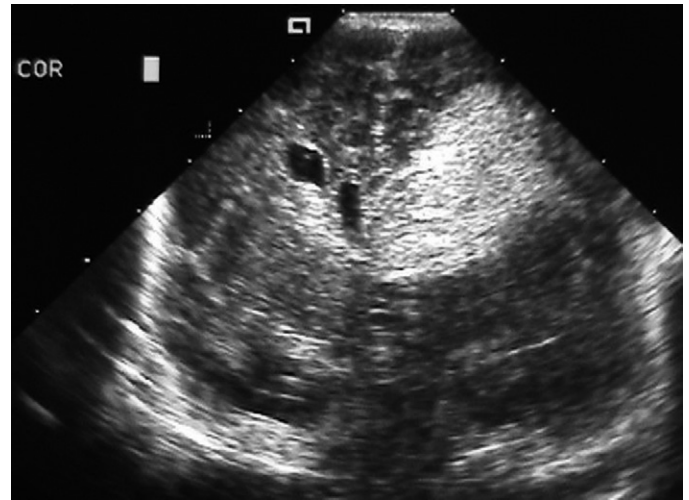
■ Coronal ultrasound scan—note the increased echodense area in the left frontal white matter conforming to the distribution of the medullary veins.
